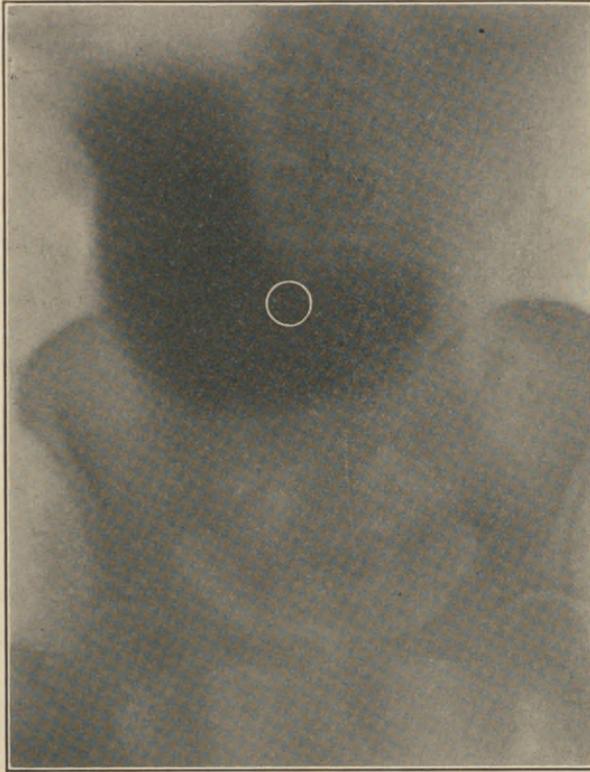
X-RAY PICTURE OF STOMACH OF A MAN WHOSE DIGESTION IS SYMPTOMATICALLY PERFECT BUT WHOSE STOMACH EMPTIES TARDILY.
